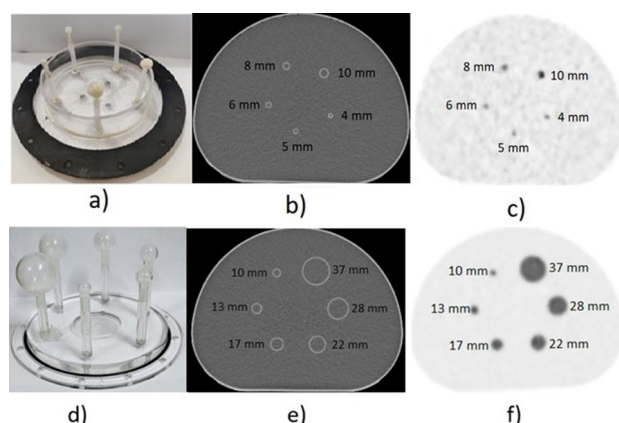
(a) Fabricated sub-centimeter lesions, (b) axial CT images, (c) axial PET images and (d) original over-centimeter lesions, (e) axial CT images and (f) axial PET images.
